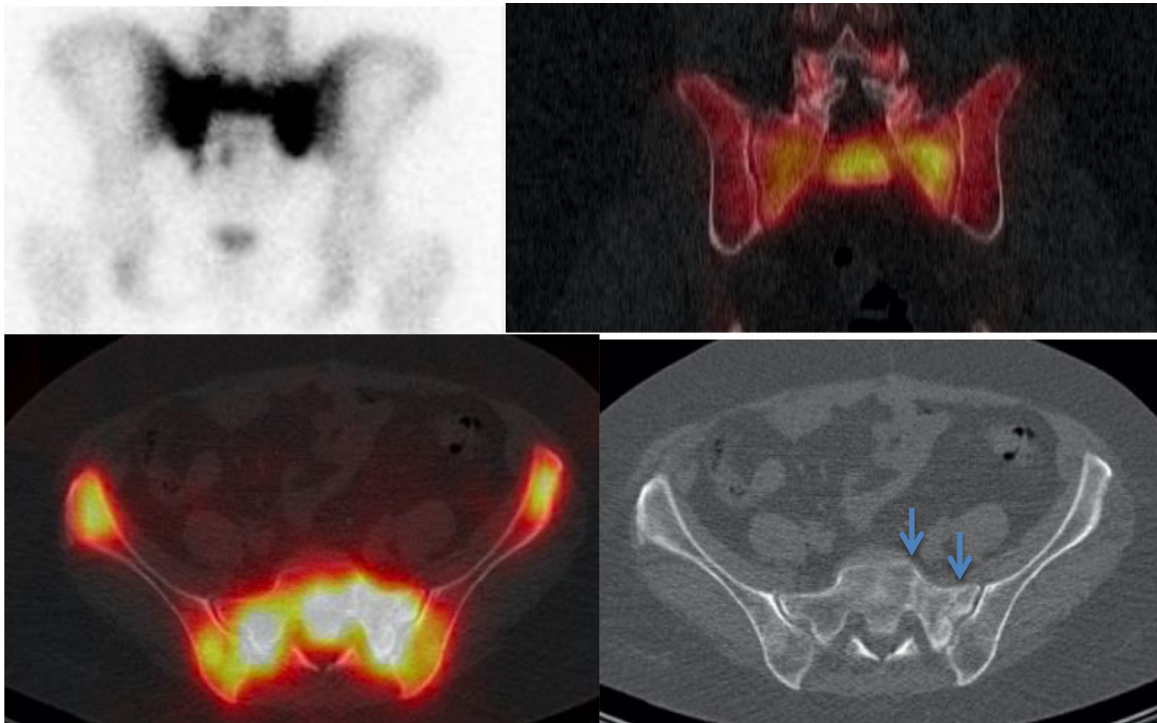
Case 1. Typical “H” sign is seen on planar bone scintigraphy and SPECT/CT images. On CT images fracture lines (blue arrows) and osteoclerosis with increased Tc-99m MDP uptake are seen in sacrum. (Color version of figure is available online.)
